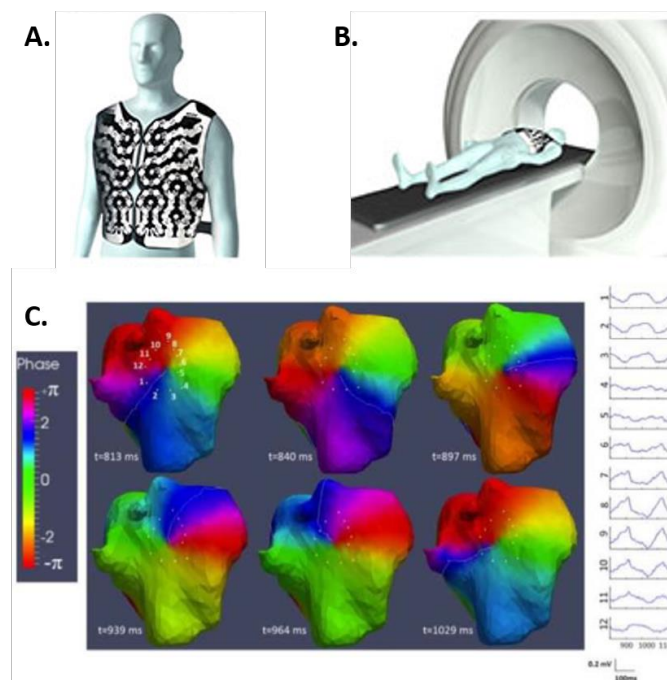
Non-invasive rotor mapping using CardiInsight. (A) A vest containing 252 electrodes is worn by the patient. (B) A CT scan is done to determine the relationship of each electrode to the CT geometry of the cardiac chambers. (C) Phase maps display the activation pattern. In this example, a rotor pivots around its phase singularity. Adapted from Haissaguerre *et al.*⁴⁷
